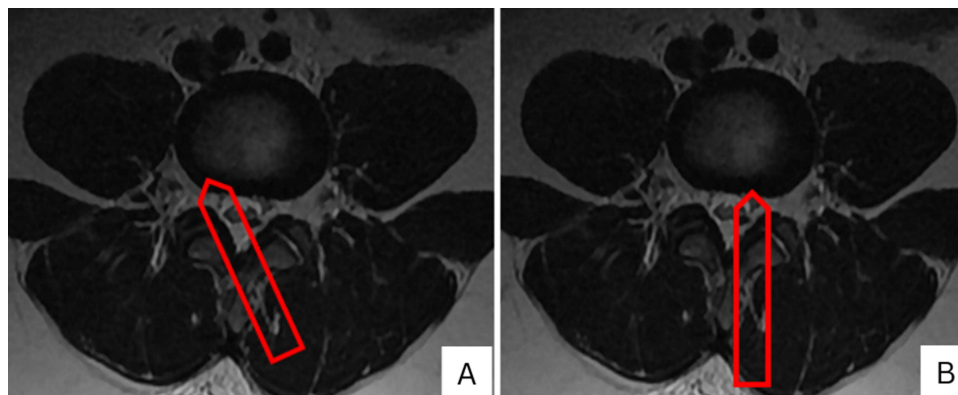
The comparison trajectory (red arrow) of contralateral and ipsilateral on axial lumbar MRI images. (A) The contralateral approach passes under the spinous process to reach the opposite side, allowing access to the lateral recess and foramen while preserving the facet joint on the working side. (B) The ipsilateral approach enters directly through the same-side interlaminar space, giving straight access to the target area but coming closer to the facet joint and exiting nerve root.
